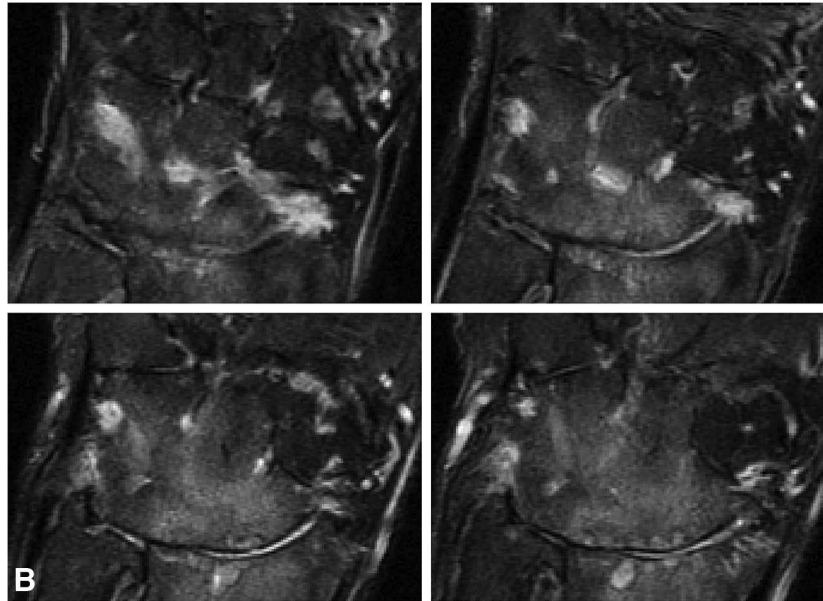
Digital clubbing of patient and brother; 1B. MRI of wrist showing joint space narrowing, erosions, and effusion; 1C. Ankle radiographs showing bilateral symmetric periostitis.
